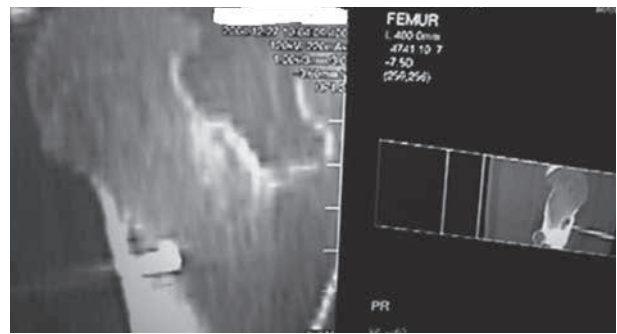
Peroperative CT-scan : coronal and sagittal sections of the pelvis showing accurate placement of a Kirschner wire into the nidus.
